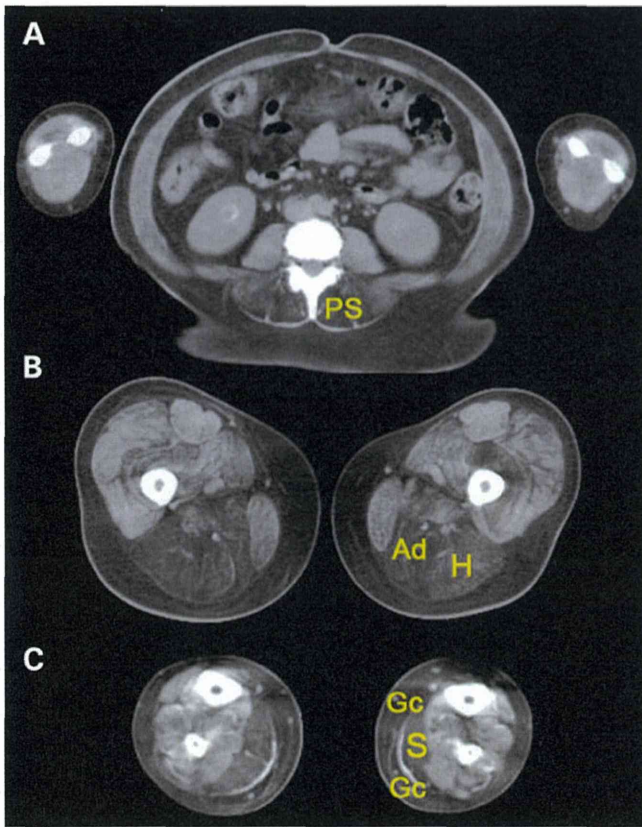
Computed tomographic imaging of TAM. Paraspinal (PS), hamstrings (H), adductor muscles in the thigh (Ad), soleus (S) and gastrocnemius (Gc) muscles of affected individual II-3a were markedly replaced by fat.
